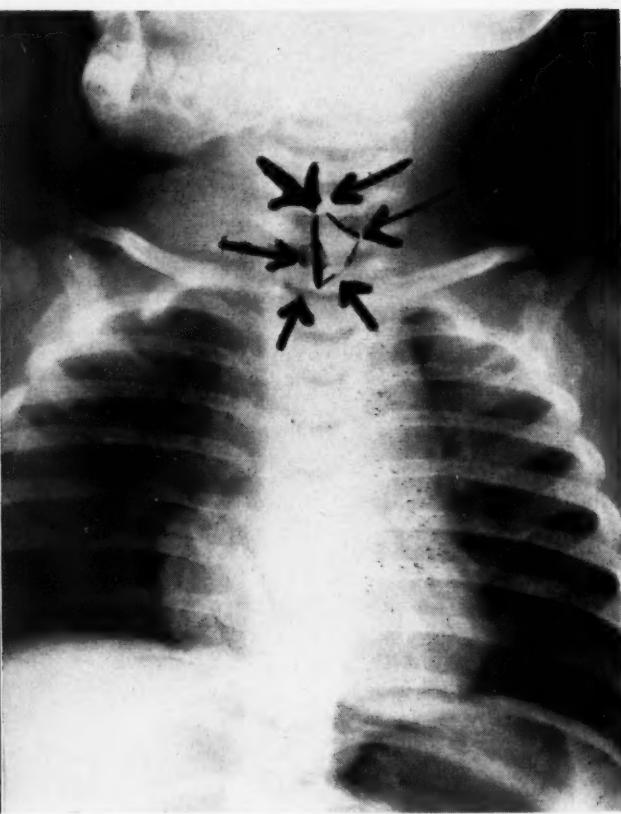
The piece of glass recovered from stool on the second postoperative day is here superimposed on chest x-ray in Figure 5.
